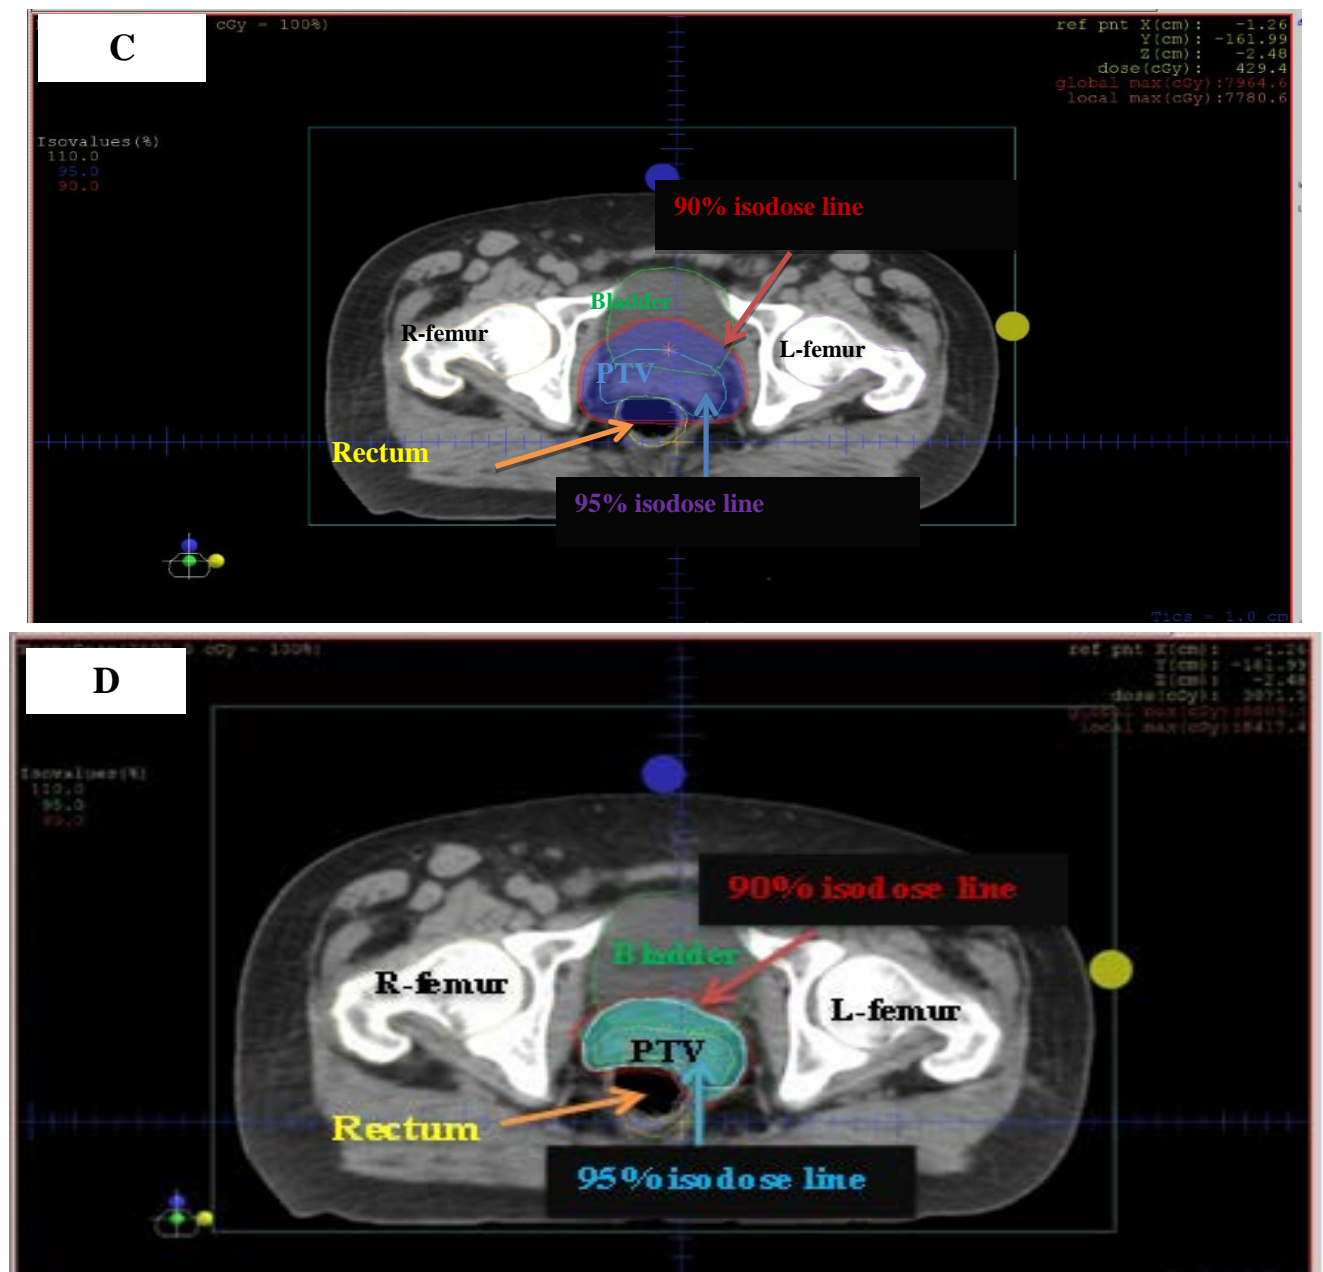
The isodose distribution in the transverse CT section for (A) 3D-CRT 6-MV (B) IMRT 6-MV (C) 3D-CRT 15-MV and (D) IMRT 15-MV
